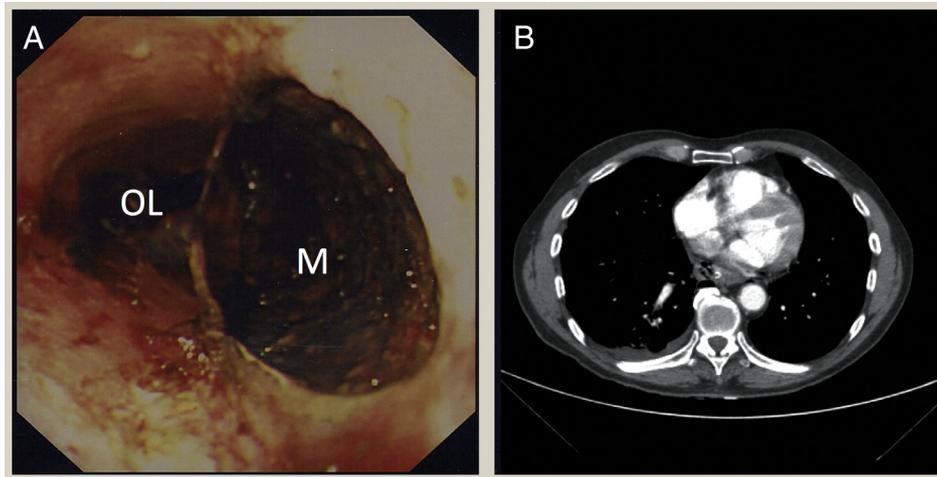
Boerhaave's syndrome. Endoscopic appearances of Boerhaave's syndrome (a). The mediastinum (M) is clearly visible and is distinct from the oesophageal lumen (OL). CT of the thorax (b) demonstrates the oesophageal perforation, with the presence of mediastinal air in the absence of pleural effusions.
